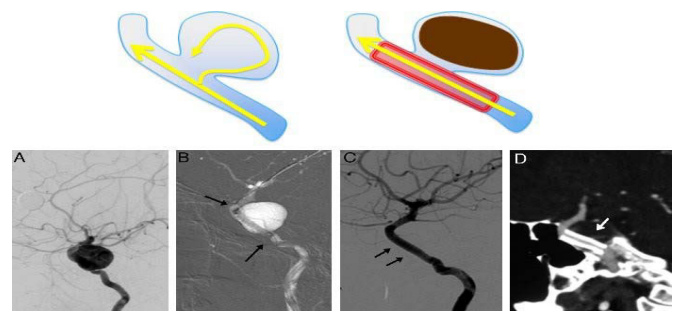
6 Flow diversion stents (A) Initial digital subtraction angiogram (DSA). (B) Digital artery map shows the covered stent deployed in the ICA (arrows). (C) DSA after conclusion of the procedure. (D) Follow-up CT-angiogram six months after the procedure.^[25]
